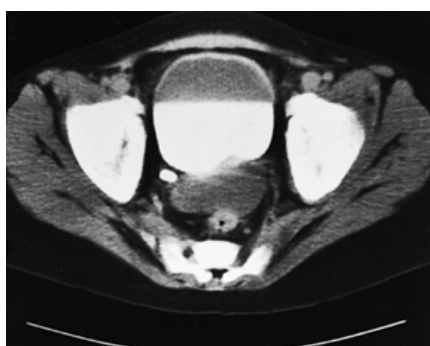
Computed tomography scan of the bladder in a 15-year-old girl with a fungus ball on the posterior wall of the bladder and severe fungal cystitis.
